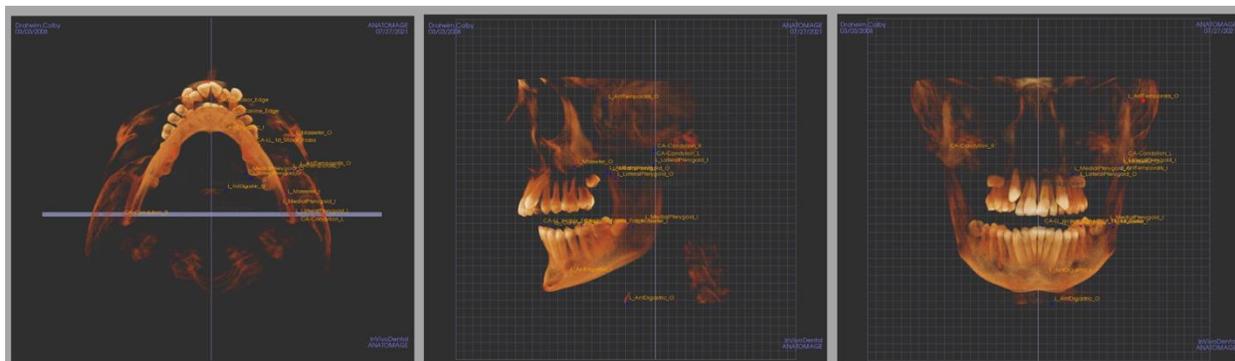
Resultant screenshots of the traced CBCT in the axial, lateral, and posteroanterior, respectively, views to be used in the creation of anatomical geometry files. Grid planes visualized.
